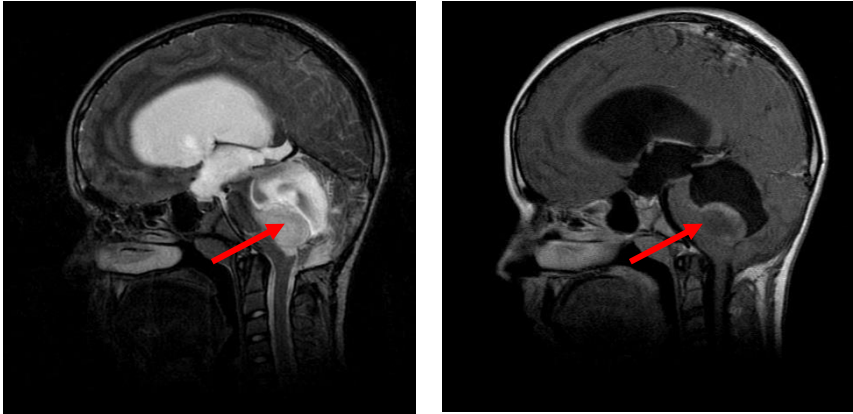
Native (T2 left) and contrast (right) MRI examination in a case of exophytic brainstem tumor projected into the IV ventricle (Personal collection of Prof. Dr. Stefan Ioan Florian)
